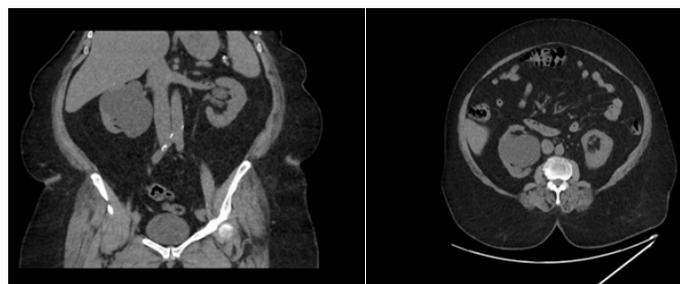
Coronal and Axial Non-contrast CT abdomen images demonstrating a large right parapelvic simple renal cyst measuring 7x5cm
